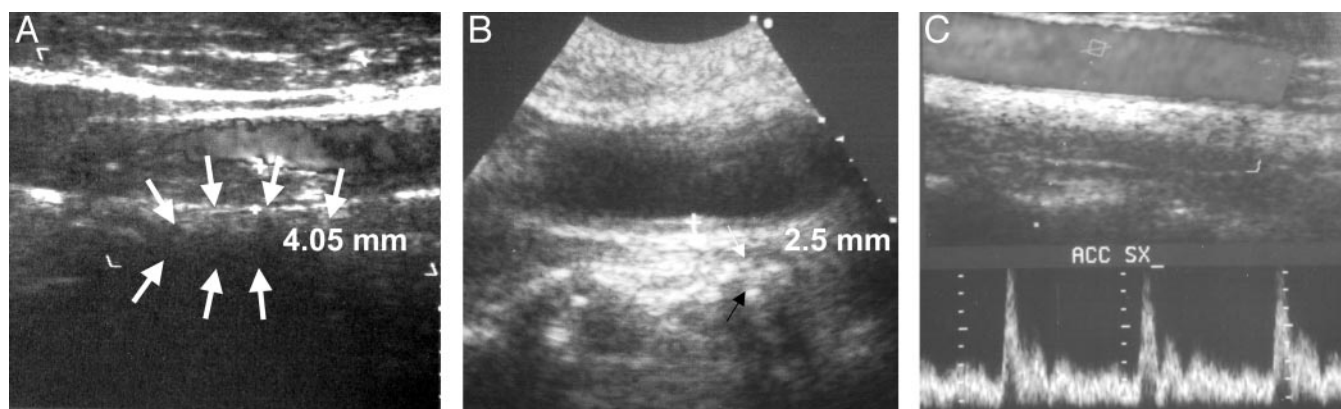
Echo-Doppler outcome. A, A lipid plaque of 4 mm (white arrows) in the left common carotid. B, Reduction of plaque size (2.5 mm) after 6 months of transdermal estradiol treatment (white and black arrows). C, In phase 7 the carotid plaques disappeared.
